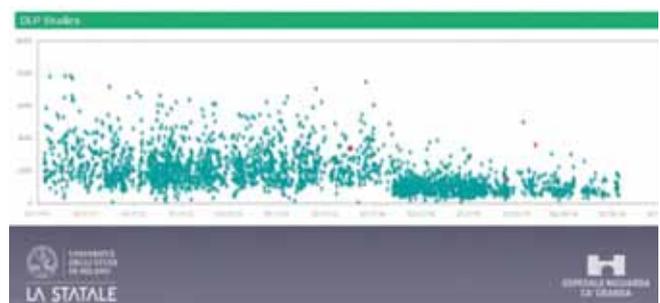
An example of the effect of use of the NEXO [Dose] system. The above figure shows the dose associated with CT of the abdomen over time. It can be seen that after protocol optimization the dose data are lower and more consistent
